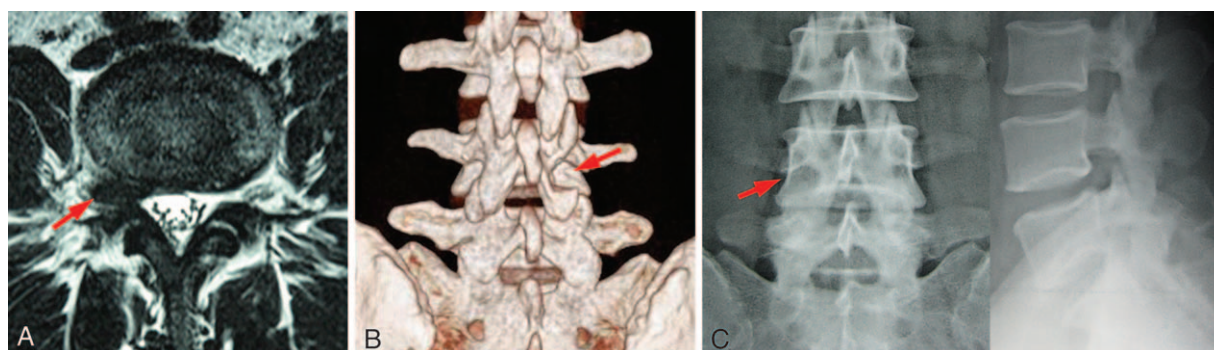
Female, 49 years old, with radiating pain to the medial malleolus along the right femoribis internus; cross-sectional MRI (A) showed intraforaminal herniations (arrow). Postoperative CT reconstruction (B) showing TFF fenestration (arrow). Radiating pain disappeared after surgery and the results were good through 12 months of follow-up. Plain radiograph 12 months later (C) showed regrowth of lamina at the periphery of fenestration (arrow). CT = computed tomography, MRI = magnetic resonance imaging, TFF = transforaminal fenestration.
